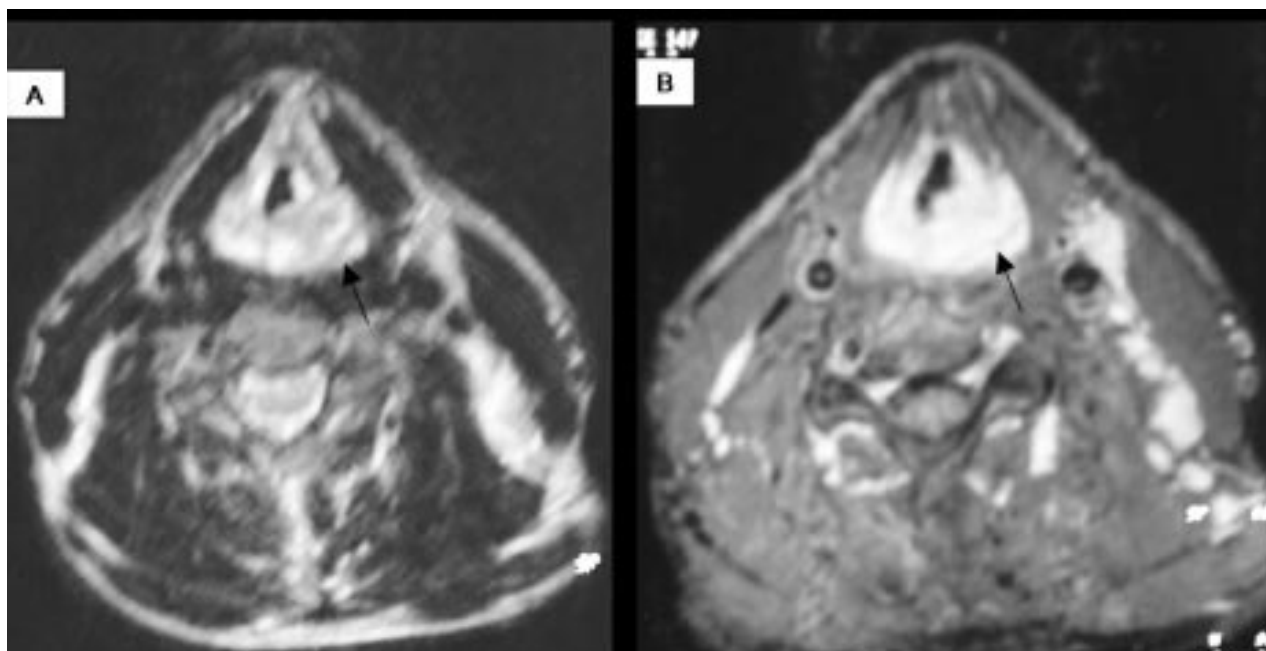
MRI view of the tuberculous lesion (arrow indicates the tuberculous involvement of the left-sided aryepiglottic fold and medial wall of sinus pyriformis). (A) T₁-weighted view, (B) T₂-weighted view.
